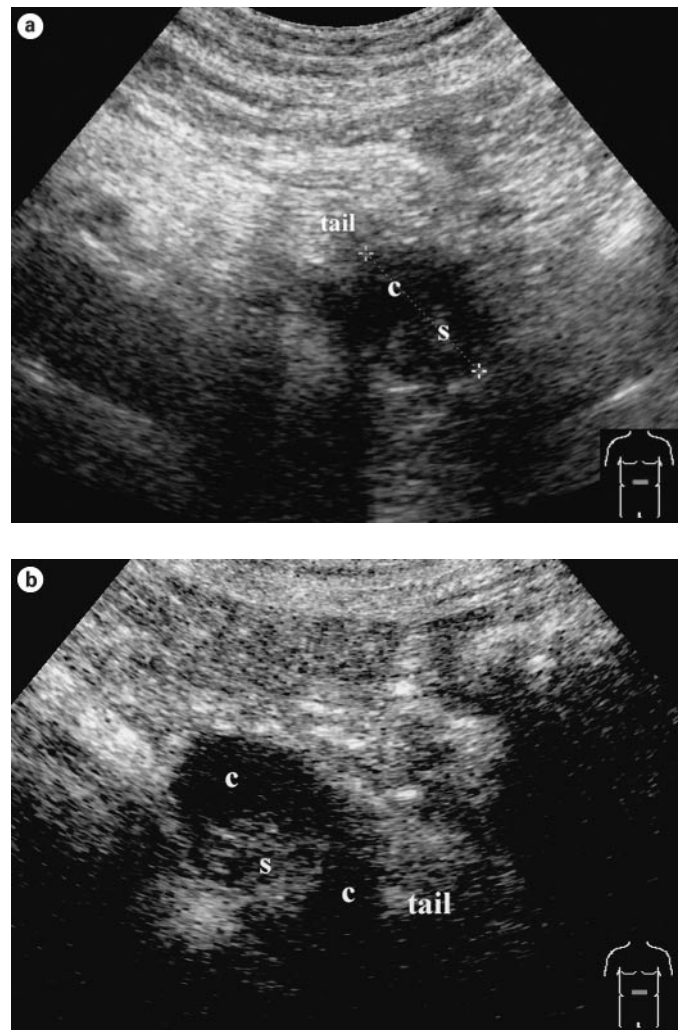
Cystadenocarcinoma at conventional (a) and echo-enhanced sonography (b). a Tumor (diameter 70 mm) with cystic (c) and solid (s) areas. b Poorly vascularized solid areas.
